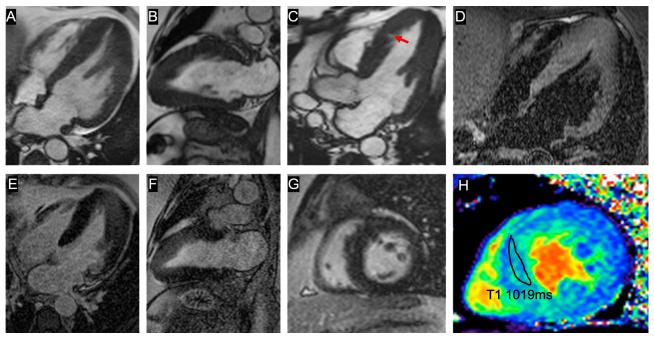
Contrast-enhanced cardiovascular magnetic resonance (CMR). Predominantly apical left ventricular hypertrophy can be observed in cine diastolic frames acquired in 4-chambers (A), 2-chambers (B) and 3-chambers long axis views. Apical insertion of the papillary muscles can be seen (A), as well as the antero-septal myocardial crypt (C, red arrow). Four-chambers T2-weighted image (D) shows no evidence of myocardial edema. Late gadolinium enhancement (LGE) acquired in 4-chambers, 2 chambers and short axis views (E, F and G, respectively) show no evidence of focal myocardial fibrosis. Native T1 value was measured as 1019 ms in the interventricular septum.
